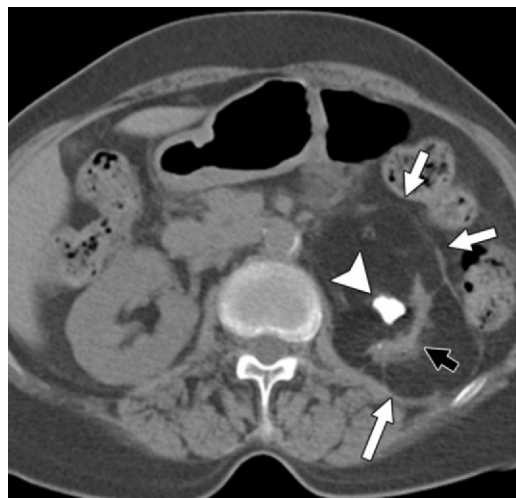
Renal replacement lipomatosis in a 47-year-old woman. Axial nonenhanced CT image shows marked thinning of the left kidney (black arrow), a renal pelvis stone (arrowhead), and expansion of perinephric fat (white arrows).
